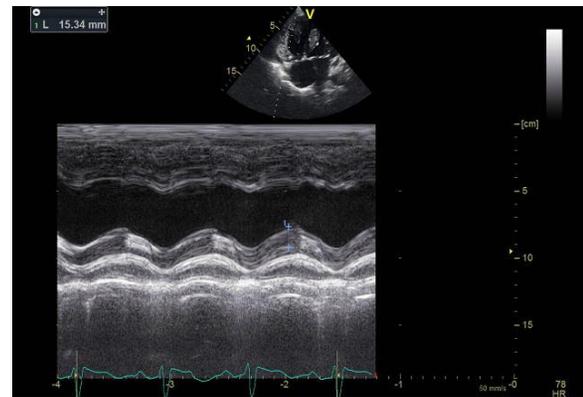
The image shows the M-mode echocardiographic image of the tricuspid annular systolic excursion (15 mm), representing fair right ventricular function.
